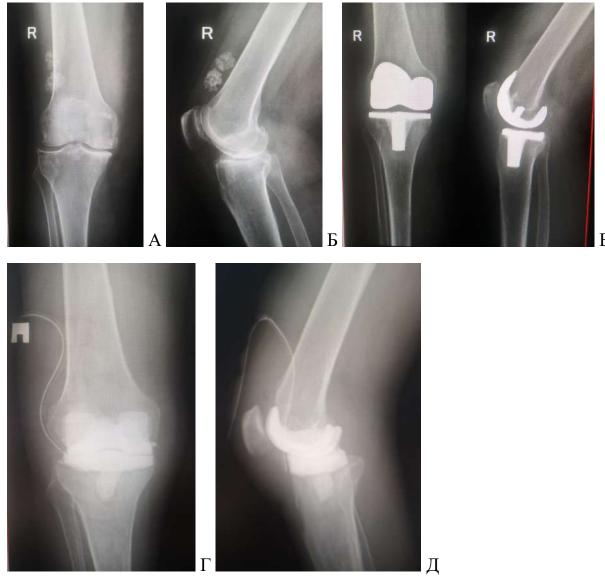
X-rays of patient B., 59 years old. A, B — pre- operative X-rays. Osteoarthritis of the right knee joint of the III st. B — X-rays after TKA. D, D — X–rays after 1 year - after removal of the arthroplasty and installation of an antimicrobial spacer. E, F, Z — MRI of the knee joint after removal of the arthroplasty and installation of an antimicrobial spacer. And, K, L, M — X-rays
